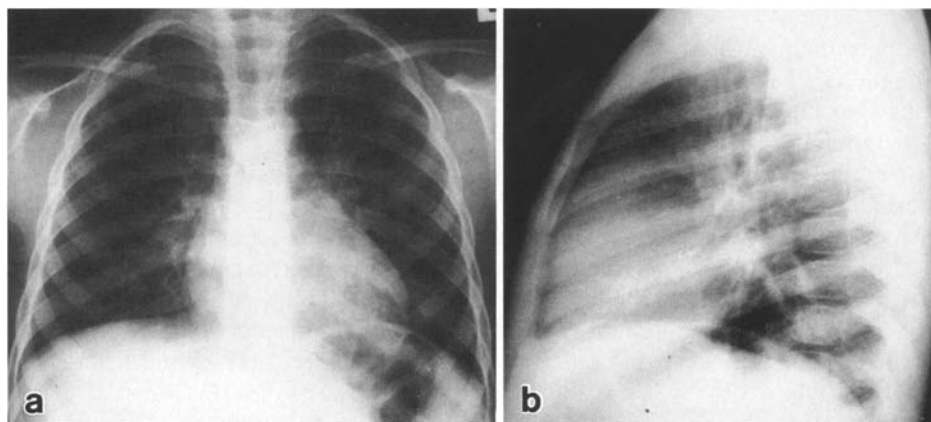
A 7-year-old boy suffering from chronic suppurative lung disease, with several episodes of left lower-lobe pneumonia. Chest X-ray from the A (AP) and B left lateral views, demonstrating mild, increased lung markings behind the heart
